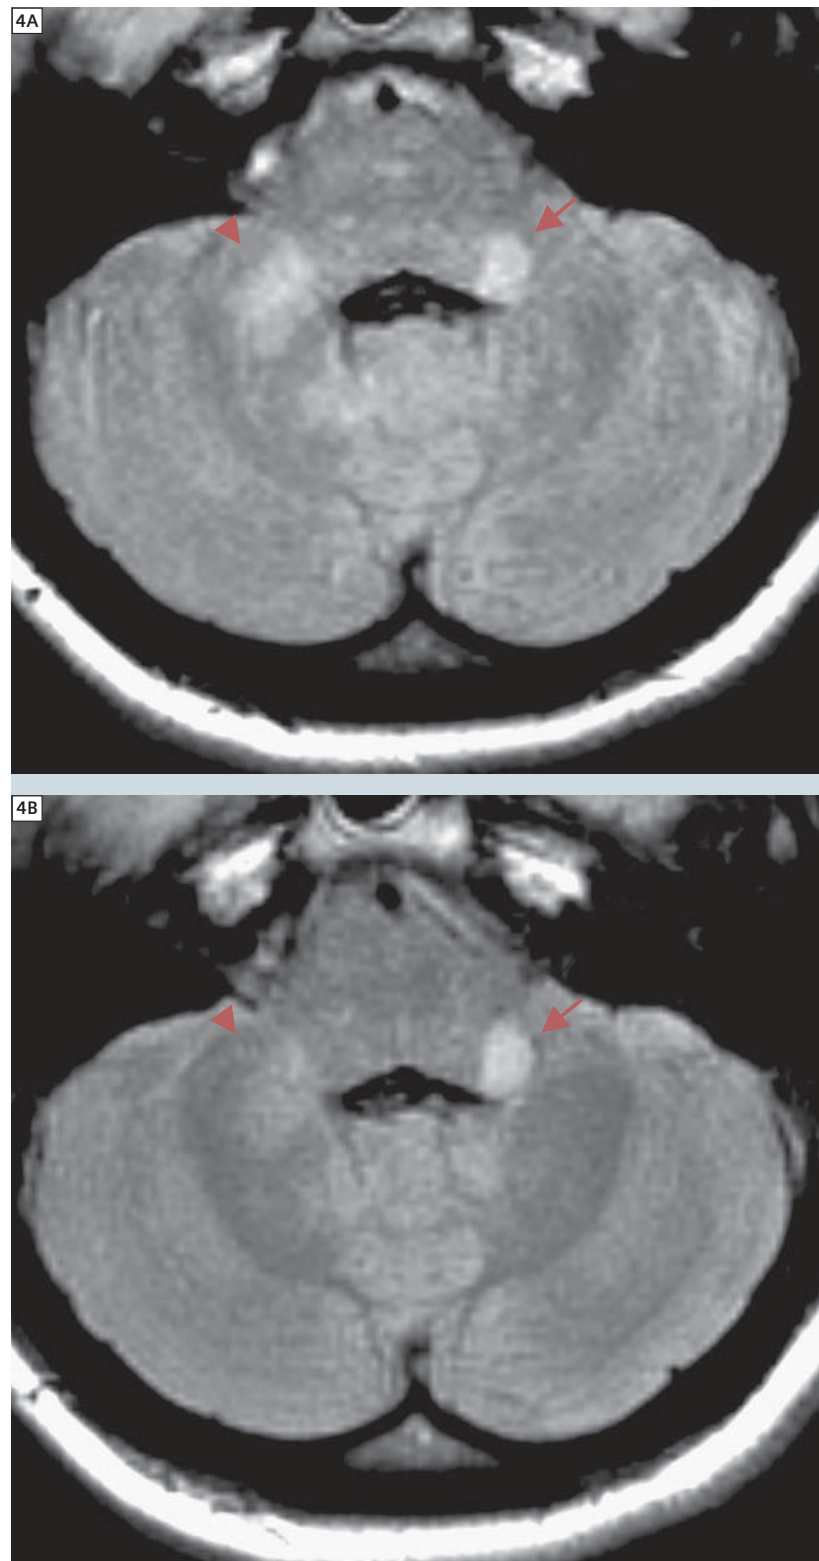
T2w FLAIR images of the posterior fossa of two different patients. Rectilinear k-space coverage (left), BLADE (right). Lesions typical of neurofibromatosis type 1: low contrast confluent (arrowhead), high contrast round (arrow). Artifacts and lesions not reliably distinguishable in conventional images (left).
